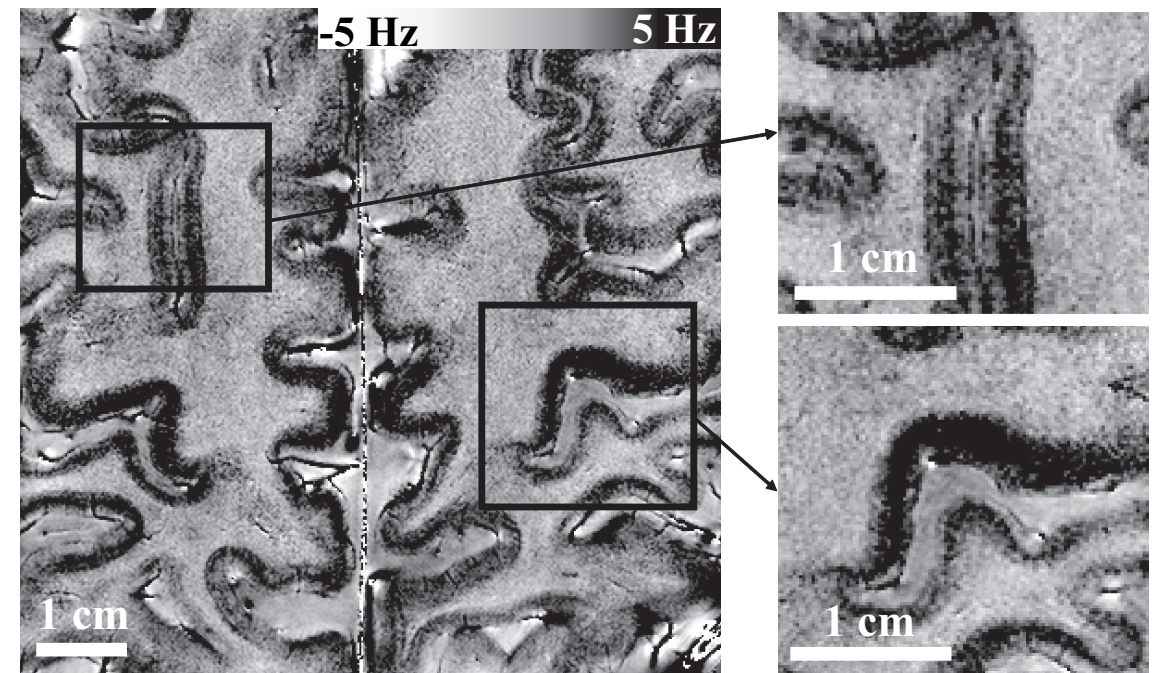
Intracortical contrast in MRI signal phase. Most cortical regions show a variation intensity that is suggestive of an underlying layer structure (*Left*). The intensity pattern varies between the different gyri, with clear differences between the upper and lower banks of the central sulcus (*Right Lower*) and cortices adjacent to the superior frontal sulcus (*Right Upper*).
